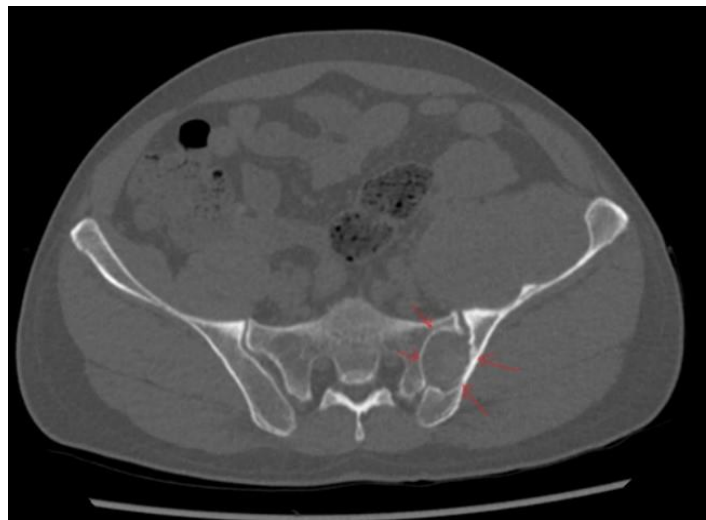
CT pelvis showed lytic lesion in the left Sacroiliac joint.
